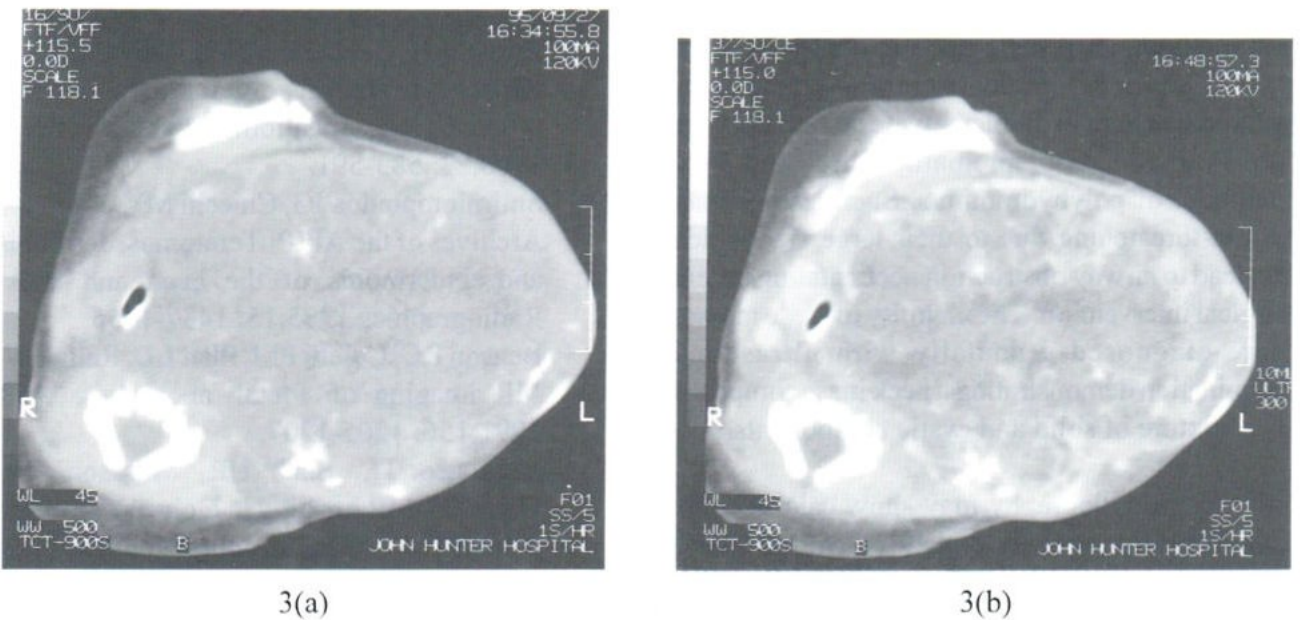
Pre-contrast (a) and post-contrast (b) CT scans demonstrate a multiloculated, enhancing, heterogeneous mass extending from the mandible to the spine and displacing the hypopharynx.
